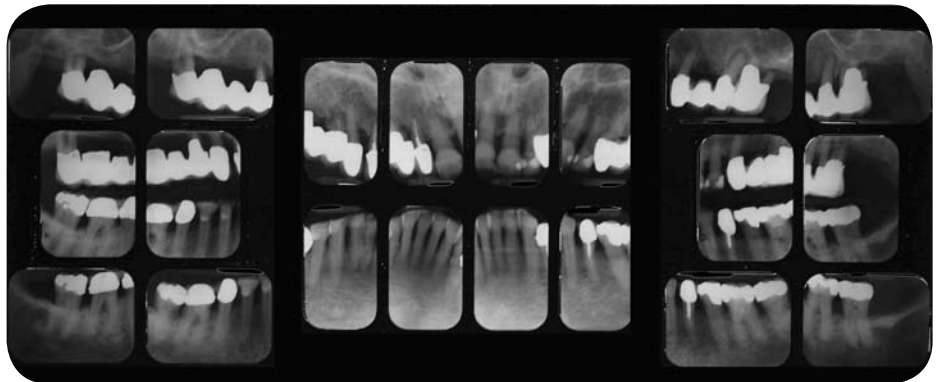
Radiographs of patient with almost intact dentition but with reduced periodontium with the signs of LPS.
